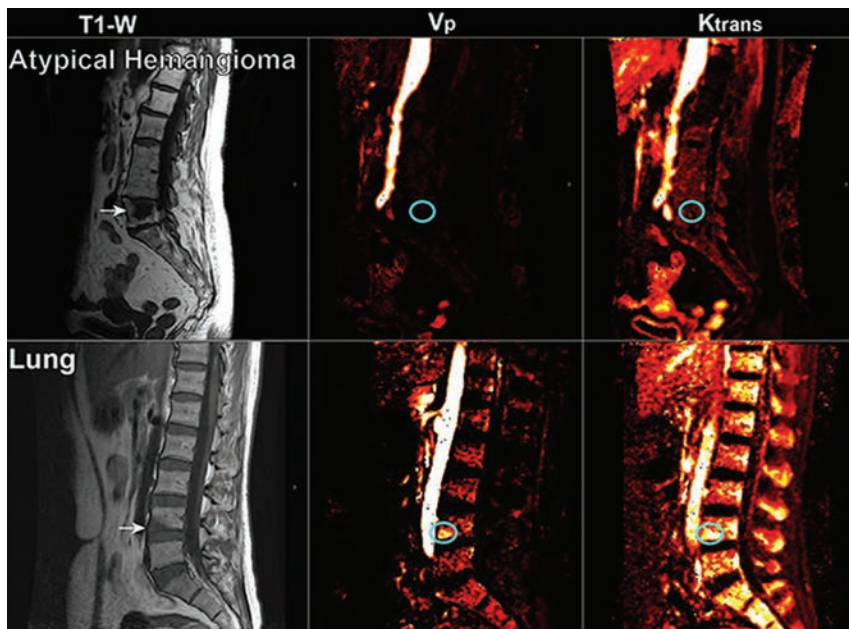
Representative sagittal T1-weighted imaging and the corresponding perfusion maps for V_p and K^{trans} parameters for atypical hemangiomas and metastasis from lung carcinoma. Arrows indicate the level of the lesion in T1WI, and the cyan circle highlights the region on V_p and K^{trans} maps where the lesion is located.
